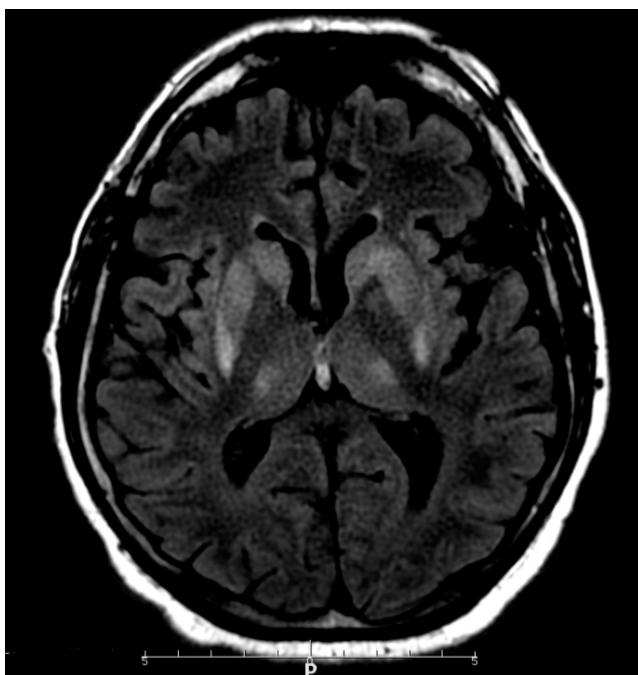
FLAIR MRI of the head – transverse section of the brain showing symmetrically distributed hyperintense areas located in the subcortical nuclei
